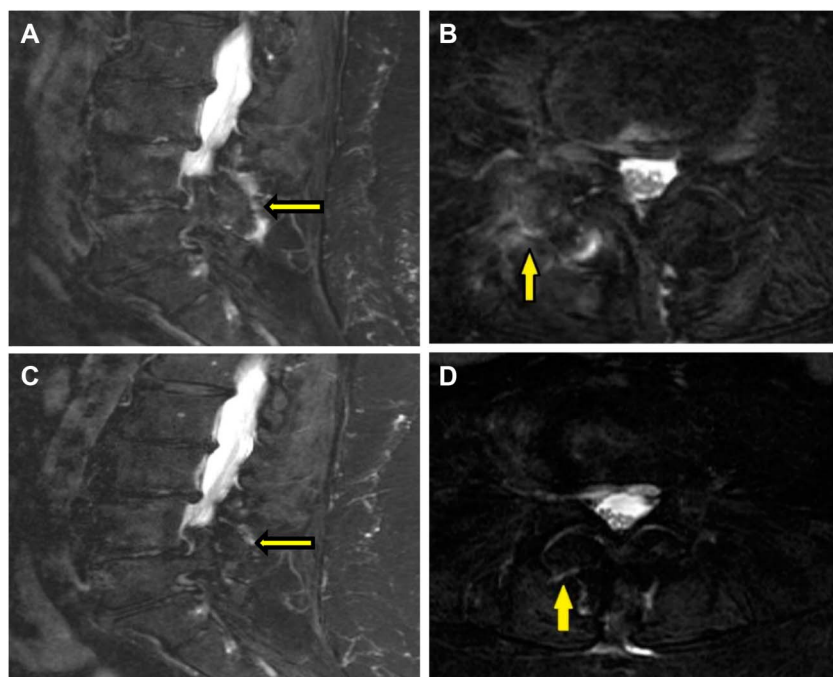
Two Dixon sagittal and axial MR images of the right L4-L5 facet joint were captured before the BM-MSC injection (A and B) and at 12 months postinjection (C and D). In images (A) and (B), abnormal increased signal (edema) involving the posterior facet joint capsules (yellow arrows) was observed, with lateral extension along the margin of the joint into the right L4-L5 neural foramen, as well as edema of the right ligamentum flavum consistent with grade 4 facet synovitis. In images (C) and (D), a reduction of edema involving the facet joint capsule was observed, with the focal residual abnormal signal at the posterior margin of the synovial capsule consistent with grade 1 facet synovitis.
